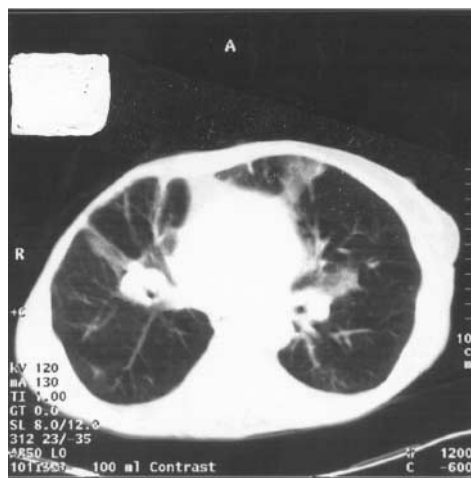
CT of thorax showing prominent peripheral infiltrates in the anterior segments of upper lobes and precarinal lymphadenopathy, an opacity at the right apex and bilateral pleural effusions
